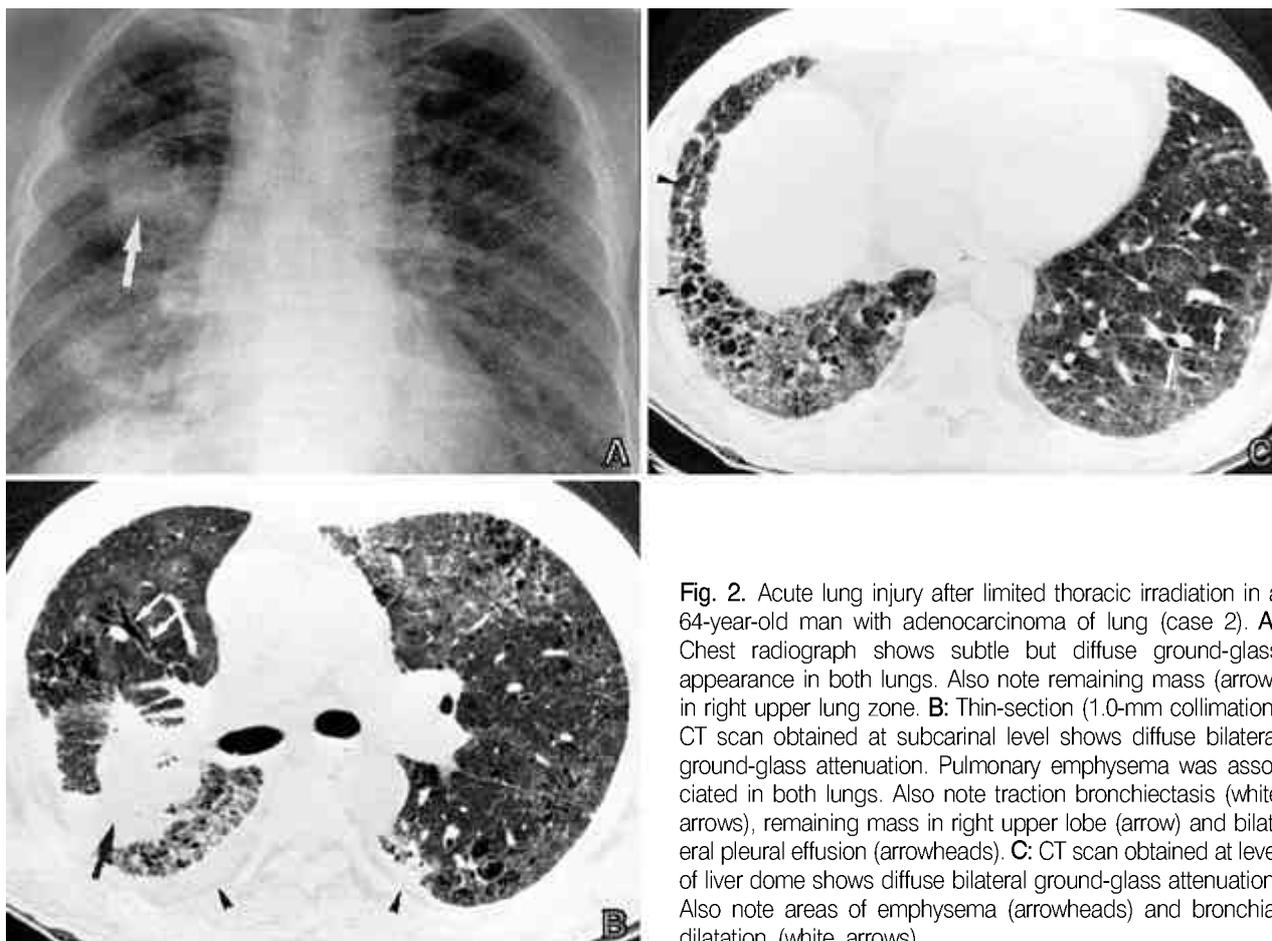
Acute lung injury after limited thoracic irradiation in a 64-year-old man with adenocarcinoma of lung (case 2). A: Chest radiograph shows subtle but diffuse ground-glass appearance in both lungs. Also note remaining mass (arrow) in right upper lung zone. B: Thin-section (1.0-mm collimation) CT scan obtained at subcarinal level shows diffuse bilateral ground-glass attenuation. Pulmonary emphysema was associated in both lungs. Also note traction bronchiectasis (white arrows), remaining mass in right upper lobe (arrow) and bilateral pleural effusion (arrowheads). C: CT scan obtained at level of liver dome shows diffuse bilateral ground-glass attenuation. Also note areas of emphysema (arrowheads) and bronchial dilatation (white arrows).
